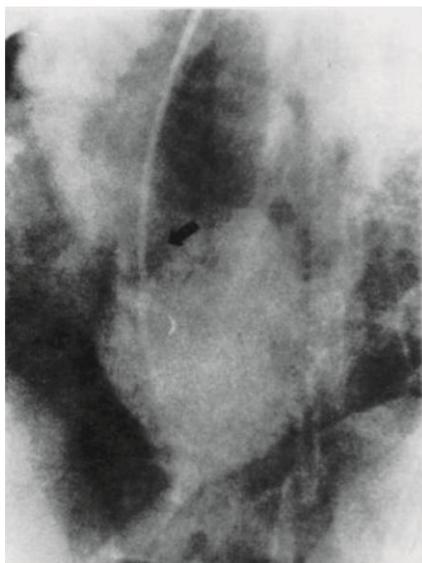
Left ventricular angiogram in left anterior oblique projection demonstrates membranous subaortic obstruction (arrow head) beneath the aortic valve. Reproduced from: Younis G A., Awdeh M, Benrey J, Price C E, Cooley A D. Discrete Membranous Subaortic Stenosis: Postoperative reversion of Aortic valve Echocardiogram to Normal. *Cardiovasc Dis.* 1976; 3(4): 424-429. Request for reproduction: Contact: <http://www.ncbi.nlm.nih.gov/pmc/about/copyright/>.
